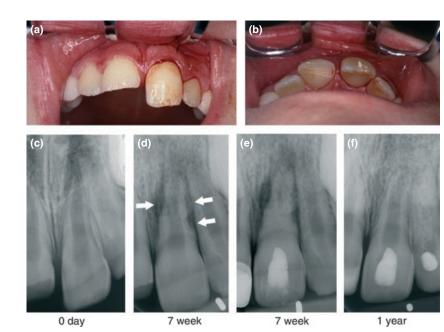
Repair-related resorption affecting the apex of the left central incisor after an extrusive luxation injury in a 13-year-old boy. (a) Frontal view at the time of injury (day 0). (b) Axial view. (c -f) Radiographs from time of injury and at follow up. Note repair-related resorption affecting the apex after 1 year (arrow).
